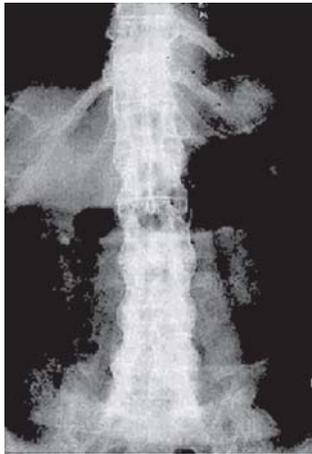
X-ray findings in ankylosing spondylitis showing bamboo spine
